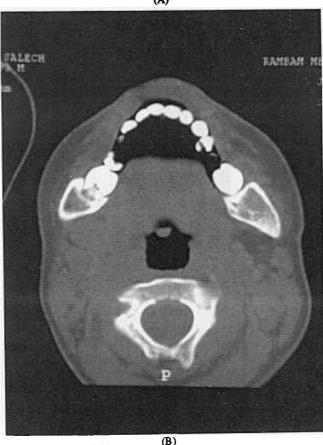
The post distraction sagittal slices of computed tomographic scans, showing the improvement in glossoptosis and airway obstruction (A). The axial CT demonstrates the increased airway as well (B).
